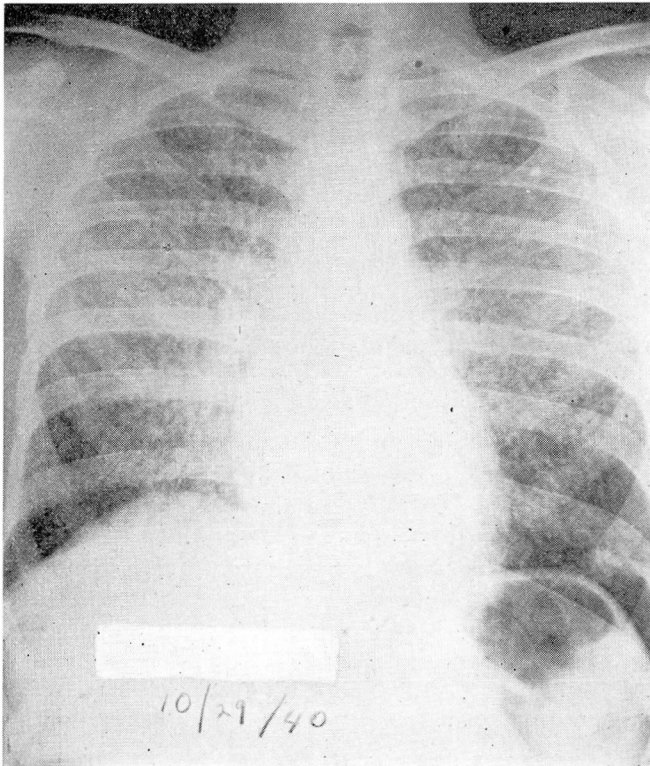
X-ray of the chest taken one week before death interpreted as showing miliary tuberculosis, later proved at autopsy. The sedimentation rate was very much elevated, and the Weltmann coagulation band = 0.
